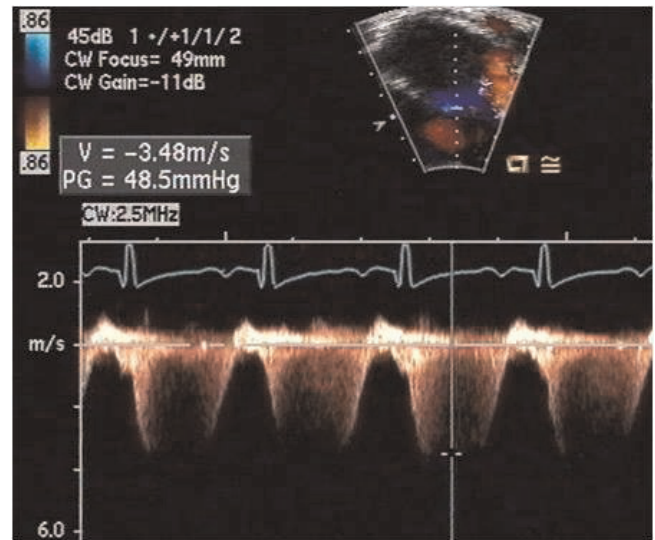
Spectral Doppler interrogation of severe tricuspid regurgitation showing a maximal instantaneous gradient of 48 mmHg. The right ventricular systolic pressure is estimated at 48 mmHg plus the right atrial pressure (more than one-half systemic pressure with systolic BP of 100 mmHg) using the modified Bernoulli equation.
